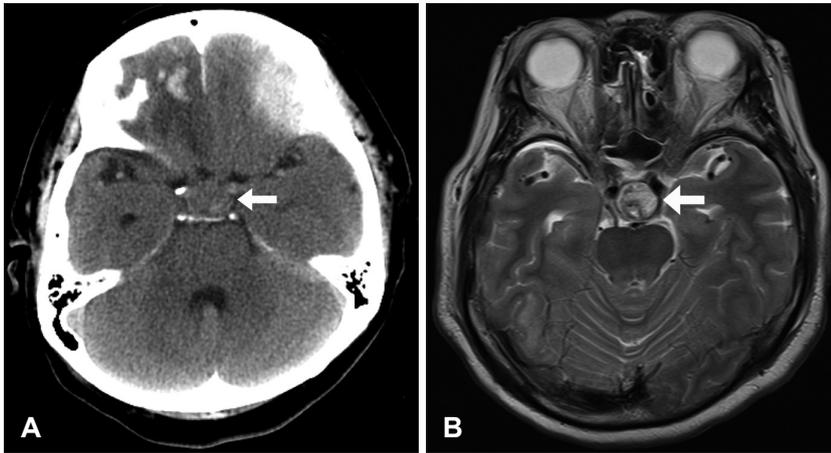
Initial computed tomography (CT) and magnetic resonance image (MRI) of the brain. Axial CT (A) and axial image of MRI (B) show multiple hemorrhagic contusions in the frontal base, falx hemorrhage and a suprasellar-extended pituitary macroadenoma with intratumoral hemorrhage (white arrows).
